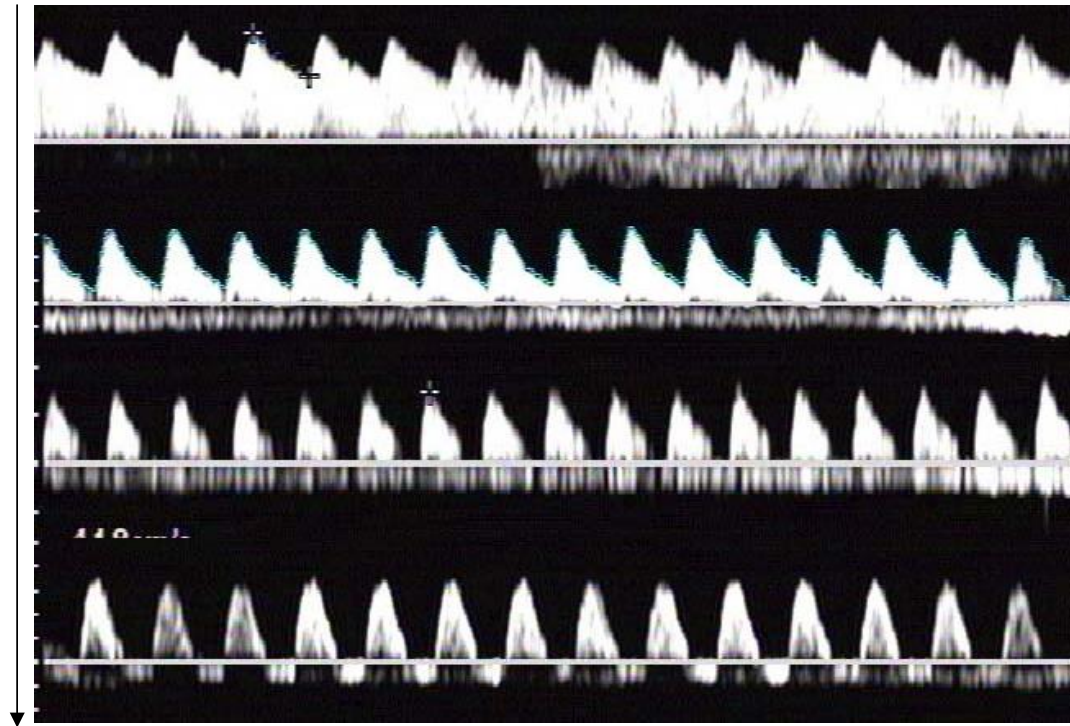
Increasing fetoplacental impedance and subsequent changes in umbilical artery Doppler waveforms
